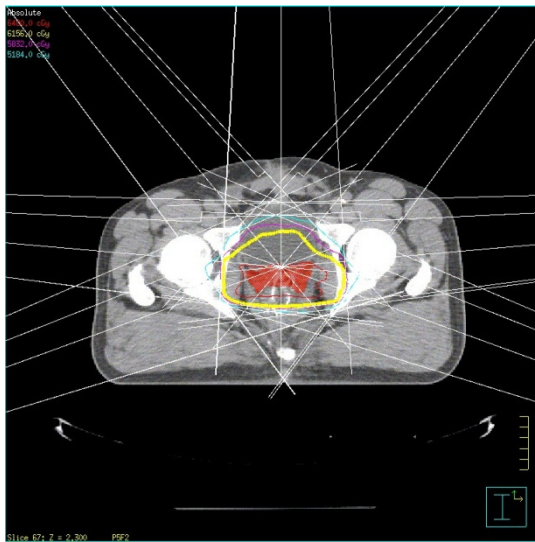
Transverse slice of a CT image at the level of the prostate bed showing seven beam angles and the resulting dose distribution.
